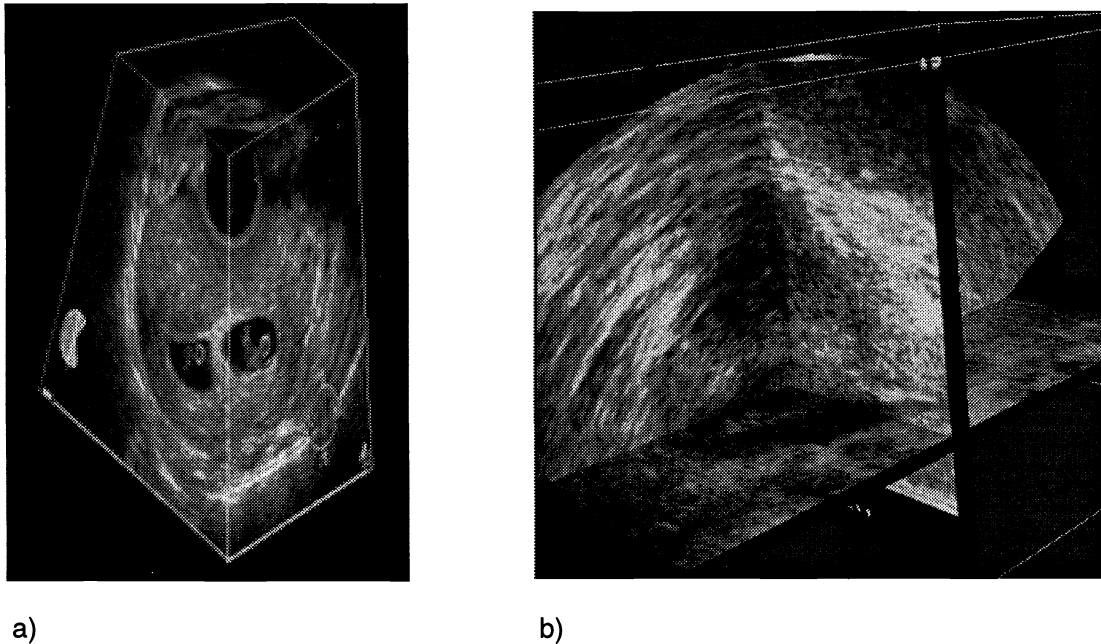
3D ultrasound images showing the two Multi-planar reformatting approaches: a) cube view approach, in which the extracted planes are texture mapped on the faces of a polyhedron. The 3D US image is of first trimester twins with implantation bleeds. b) Crossed planes view or a prostate, in which the extracted planes are shown intersecting with each other.
